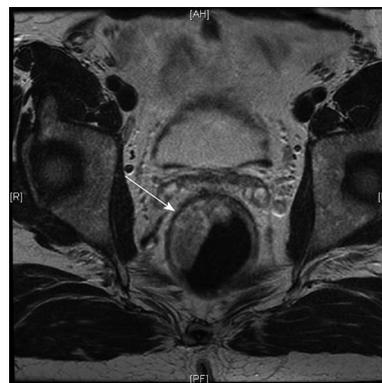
Coronal T2 W magnetic resonance imaging (arrow) showing the intact muscularis propria in a patient with rectal cancer. Radiologically staged as T₁ or T₂.
